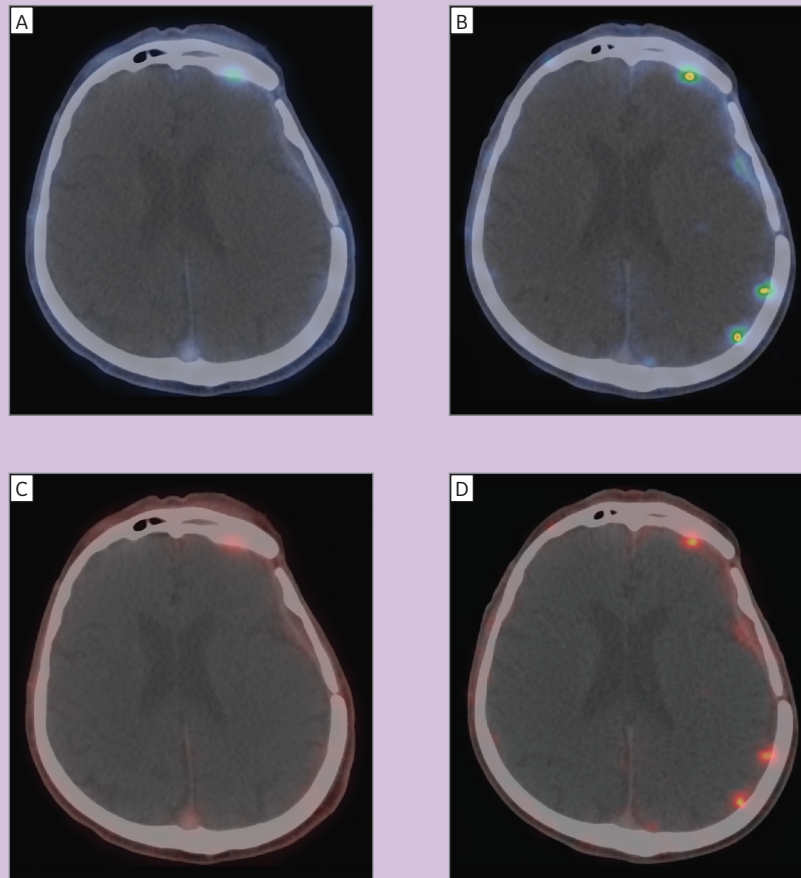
In the (B, D) Discovery IQ 5-Ring PET/CT images, the lesions are clearly visible compared to the (A, C) TOF images.
